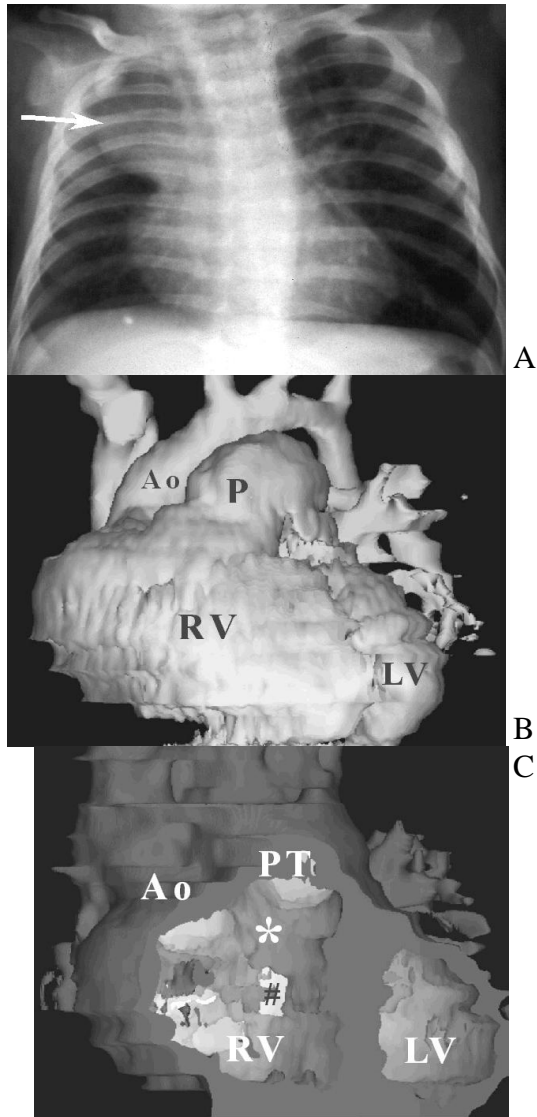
Non-committed VSD type of DORV. (A) CXR showed normal heart size with bulging right upper mediastinum (arrow) by prominent thymus. (B) 3D CTA revealed both PT & Ao arose from the RV with PT left anterior ( $58^{\circ}$ ) to Ao. (C) 3D inner cardiac view demonstrated the location of the VSD(#) at the membranous septum away from both great arteries. The conus septum (\*) ran in oblique coronal plane. Ao=aorta; LV=left ventricle; PT=pulmonary trunk; RV=right ventricle; VSD=ventricular septum.
